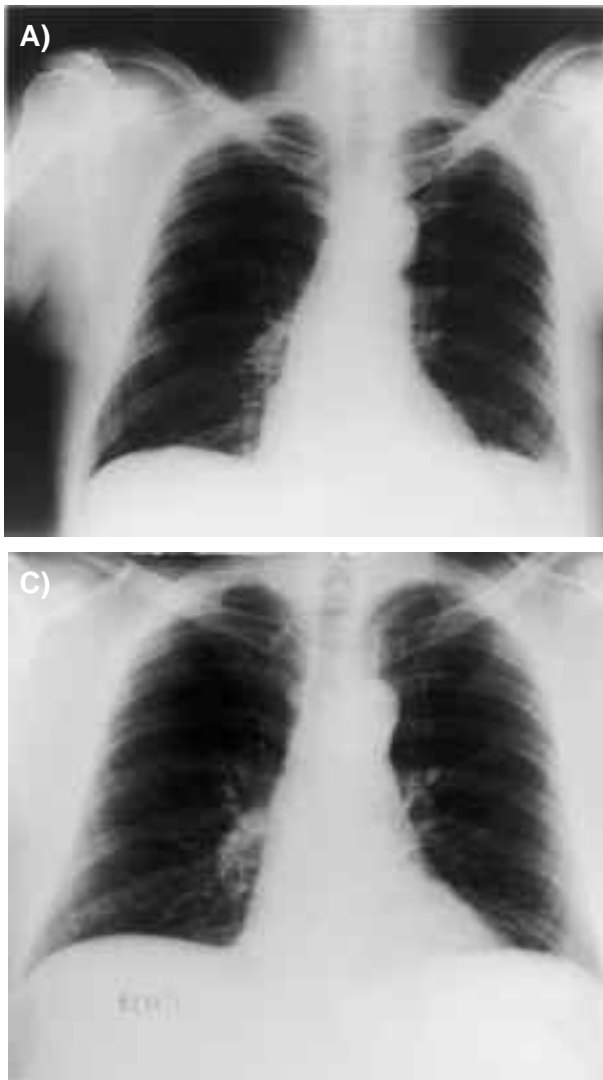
A. Chest X-ray at the time of nephrectomy: no lung or pleural metastases are visible (although a CT scan performed at the same time showed three small parenchymal metastases). B. Progressive disease: X-ray taken 11 months after the beginning of immunotherapy (after three cycles) showing two bilateral nodular opacities, (3.9 x 3.6 and 1.8 x 1.1 cm) localized pericardially in the upper right and lower left lobe. C. “Late” complete remission: X-ray taken 16 months after the beginning of immunotherapy (after five cycles) demonstrating the disappearance of the lung metastases; the findings were confirmed by CT.
